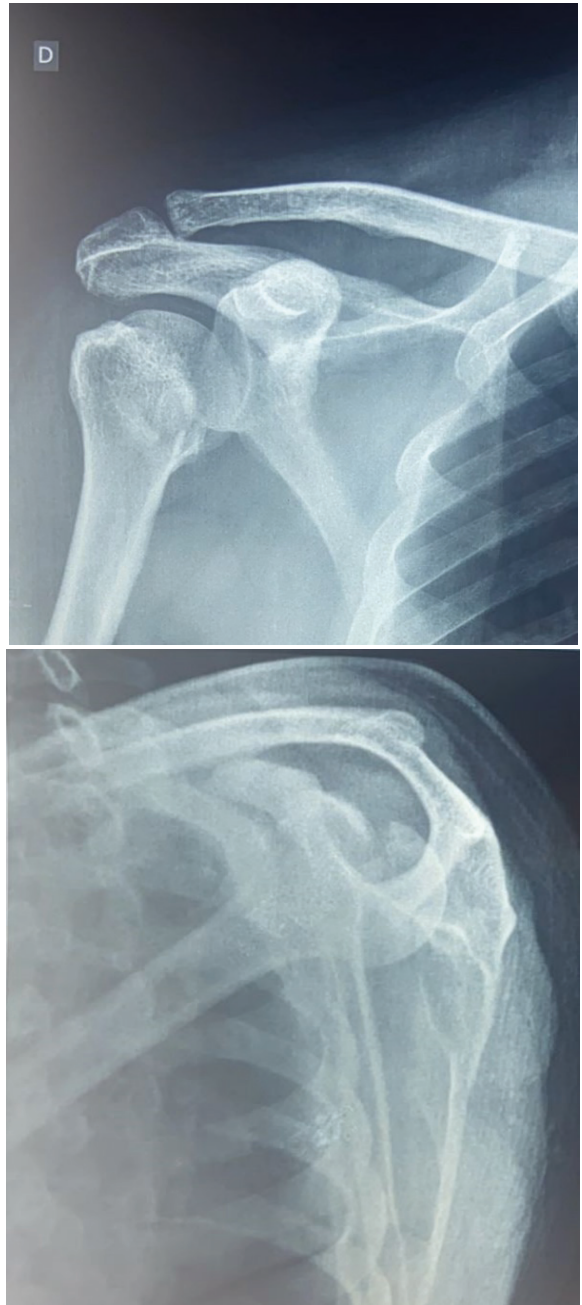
Corrected anteroposterior radiographs of the right shoulder and scapular profile demonstrating fracture-dislocation.
